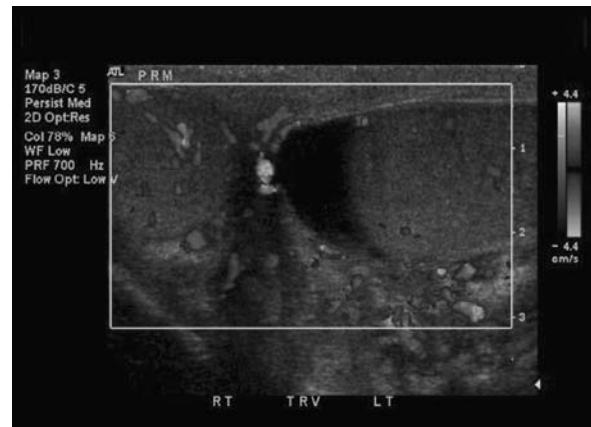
Epididymitis. Ultrasound image of enlarged epididymis seen on left side of image, testis on right. Color Doppler flow ultrasound reveals increased blood flow to inflamed epididymis.
